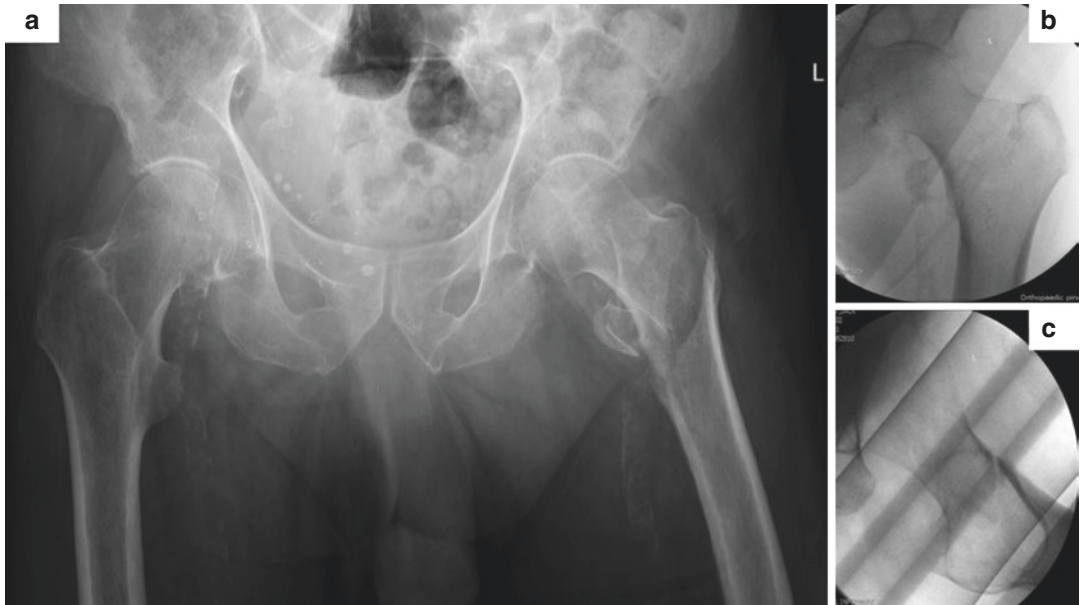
(a) Preoperative AP pelvic radiograph showing a displaced left pertrochanteric hip fracture; (b) AP and (c) lateral fluoroscopic images demonstrating satisfactory closed reduction after application of axial traction and internal rotation
